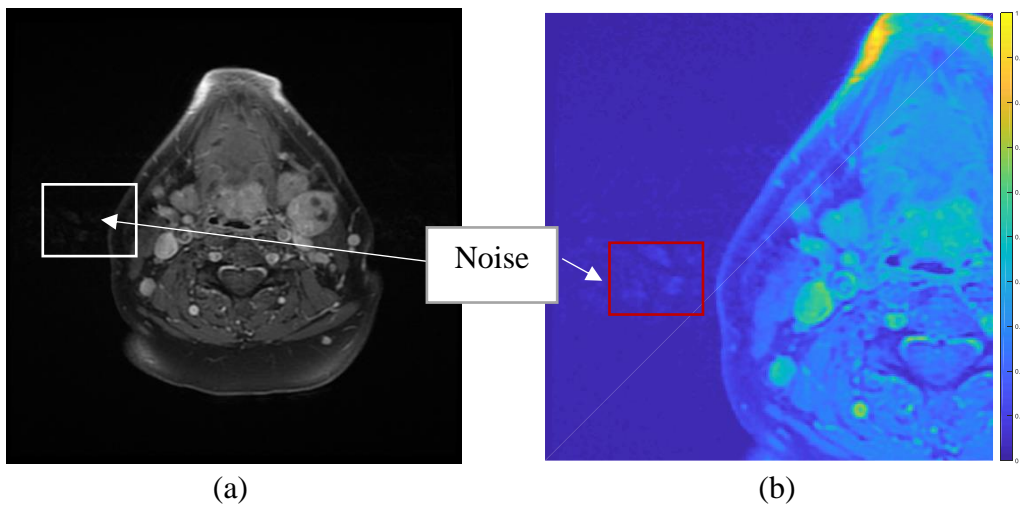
An MRI slice with noise (marked with arrow and text box). (a), a slice, (b), zoomed region of left slice, and converted to parula colour space to make it more visible.
